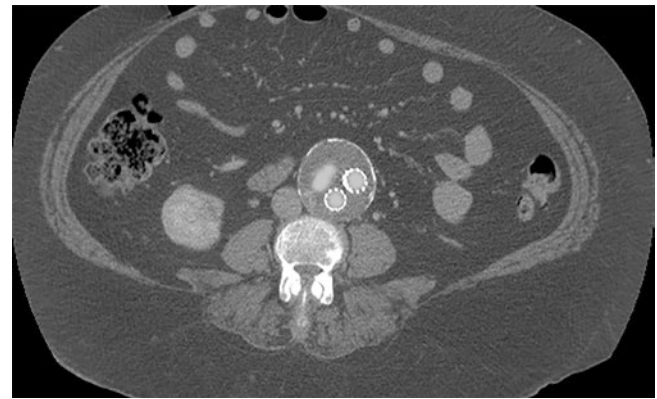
Computed tomographic scan demonstrating the presence of an endoleak after endovascular repair that resolved after a secondary intervention
